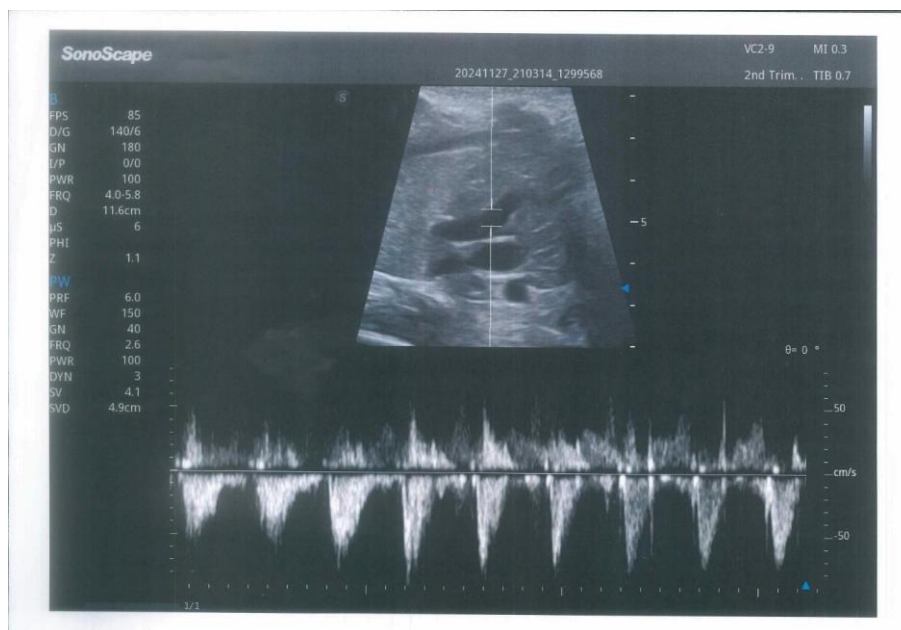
A 27 years old 3rdG, admitted for routine antenatal u/s evaluation, GA 39 weeks + 1day, SLF, HR (134b/m) with adequate movement, AFI (12cm), placental grading grade 3, colon grading grade 2, Doppler examination: MPA RI(0.75), PI(1.7), AT(57ms), ET(175ms), AT/ET(0.32), The neonatal outcome delivery within 24 hours after u/s examination _NICU admission for RDS (NO) .
